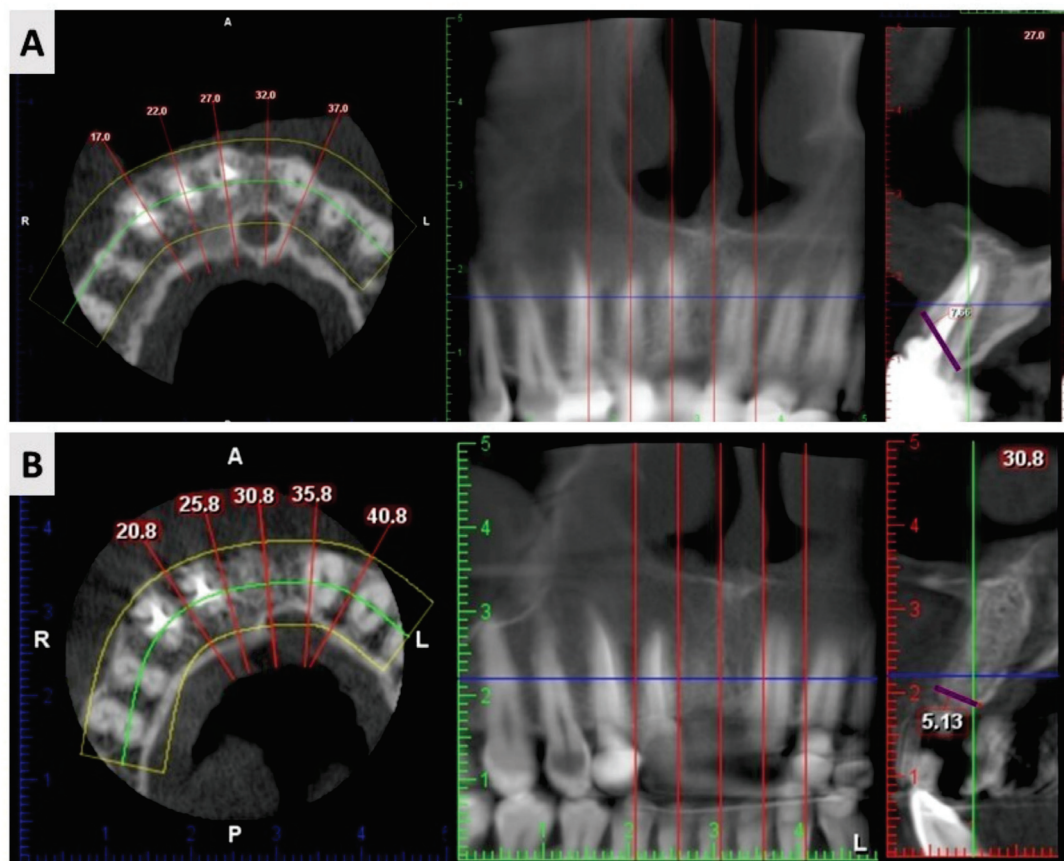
CBCT assessment protocol. The buccolingual dimension was measured between the most prominent points buccally and orally (purple marked line) at two time points—before extraction (A) and four months after (B).
